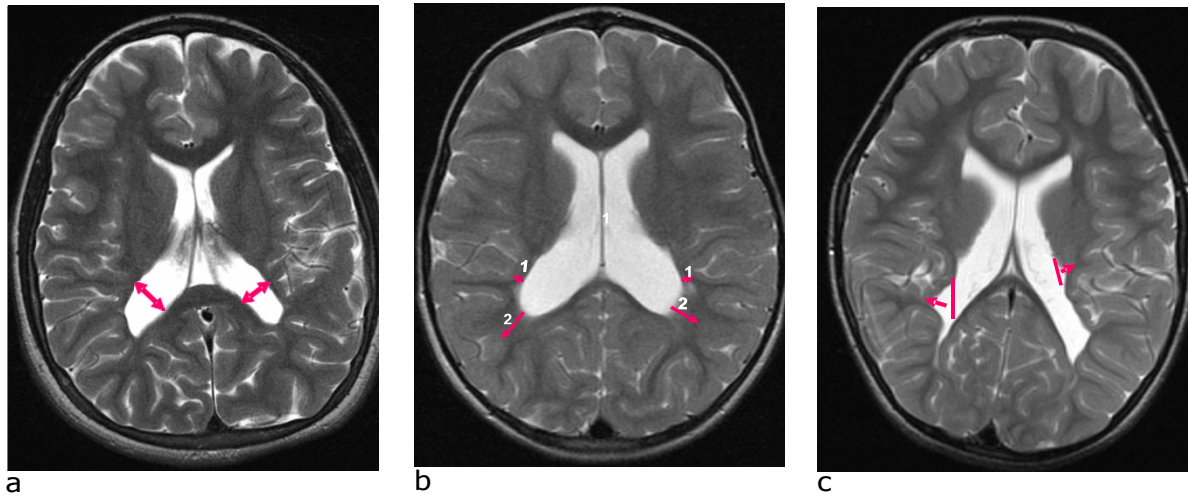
Axial T2-weighted MR images show: a: width of the posterior horn of the lateral ventricle (right, left) at its widest point, b: distance between the lateral ventricles and the cortex (right, left) (arrow number 1), distance between the lateral expansion of the ventricles and the cortex (right, left) (arrow number 2). c: depth of lateral expansion of lateral ventricles.
